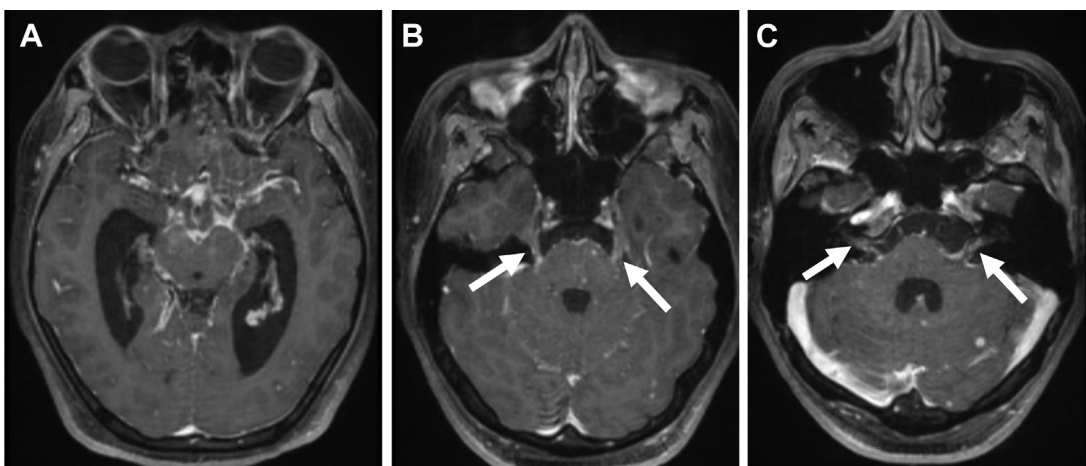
Tuberculous meningitis with cranial nerve involvement. Axial T1-weighted postcontrast MR images show thick basal cisternal enhancement with hydrocephalus (A), diffuse thick enhancement along the cranial nerve V (B), and VII/VIII complexes (arrows) (C).
